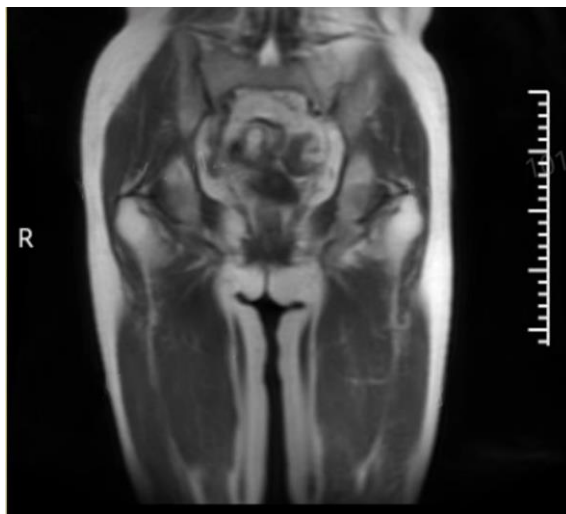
The magnetic resonance imaging of anal canal of case 2 showed anal fistula and anal abscess
